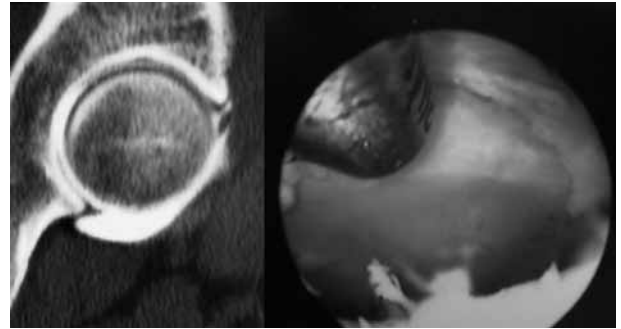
CT-arthrography findings were similar to arthroscopic observations in 81% of cases. In this particular case, CT-arthrography shows a degenerative labral tear discovered by hip arthroscopy.
